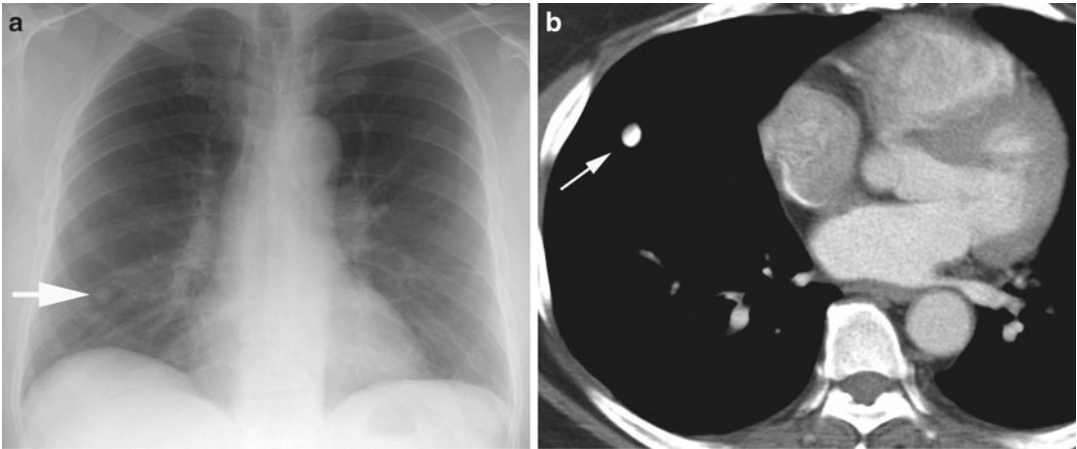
Calcified pulmonary nodule. (a) Frontal chest radiograph reveals well-circumscribed 0.8 cm dense nodule (arrow). (b) Axial CT confirms nodule as densely calcified (arrow)
